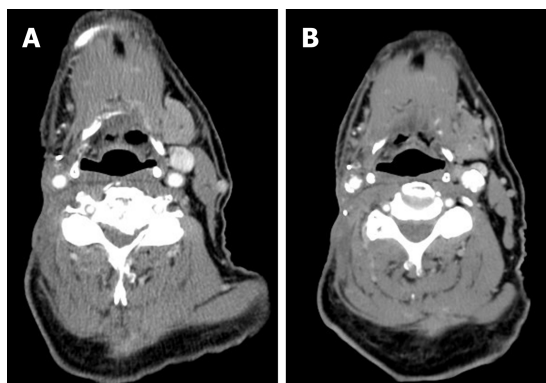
Contrast-enhanced computed tomography scan of neck. A: After completion of 6-mo erlotinib treatment; B: Seven mo after discontinuation of erlotinib treatment. Both showed resolution of right neck focal skin irregularity and right submandibular lymphadenopathy as shown in [Figure 1](#).
